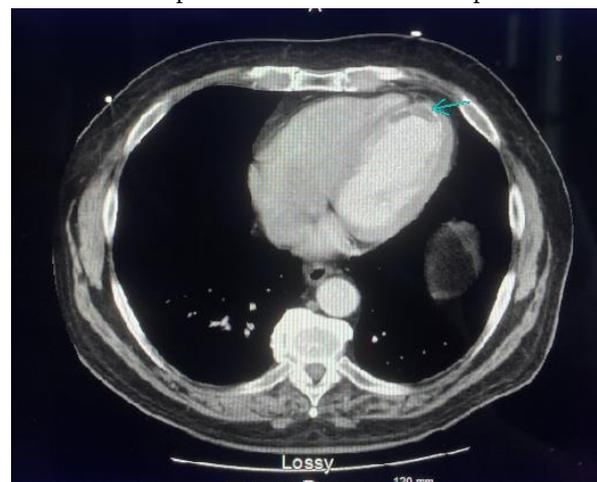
Filling Defect in Left Ventricular Cardiac Apex visualized on CT scan
